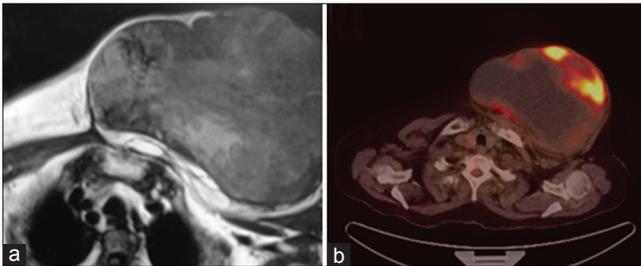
Pleomorphic liposarcoma: A 65-years-old female with chest wall pleomorphic liposarcoma. on magnetic resonance imaging; axial T1W image (a) show heterogeneous tumor; positron emission tomography-computed tomography showing peripheral uptake (b) with large necrotic areas standardized uptake value (SUV) maximum value of 21 and SUV average of 2
